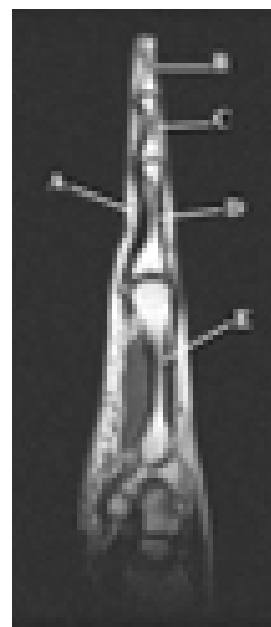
T1-weighted sagittal hand through index finger. A-flexor digitorum indicis tendon, B-distal phalanx, C-middle phalanx, D-proximal phalanx, E-2nd metacarpal
